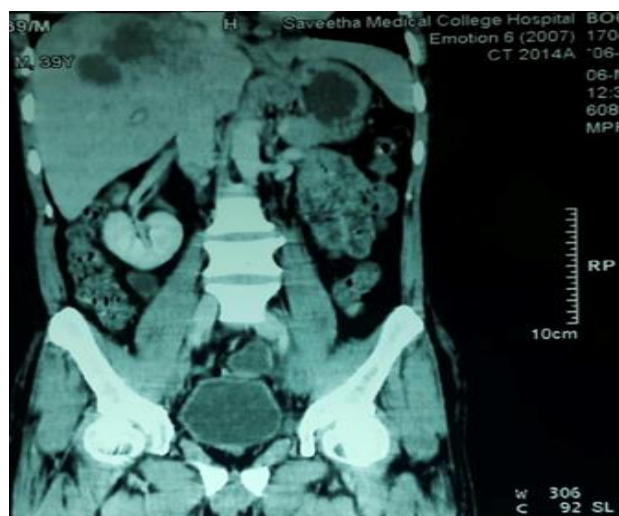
CT showing multiple liver abscess - Sagittal cut.
